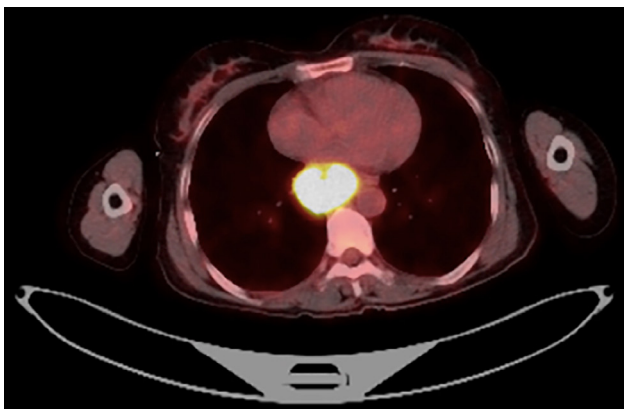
PET/CT image of the lesion in the lower thoracic esophagus.
